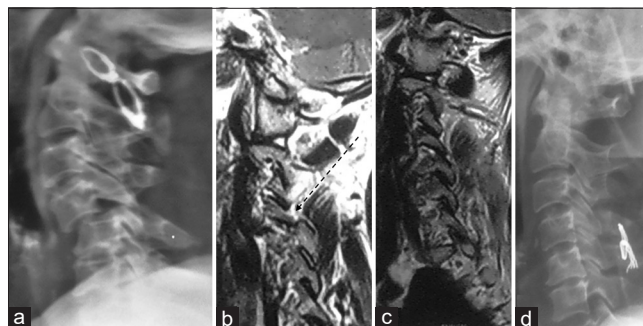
Radiographs of patient number 4. (a) X-ray showing unifacetal dislocation at C4-C5, (b) para-sagittal magnetic resonance imaging showing the dislocated facet (arrow), (c) para-sagittal magnetic resonance imaging of the other side showing reduced facet, (d) postoperative X-ray showing reduction of dislocation and fixation with interspinous wiring
